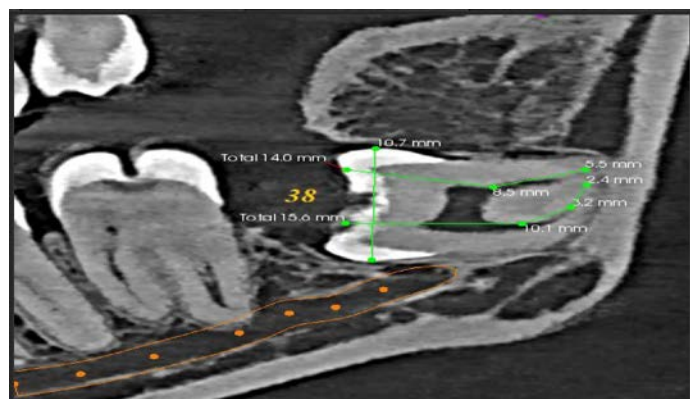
CBCT Measurements For Left Third Molar
